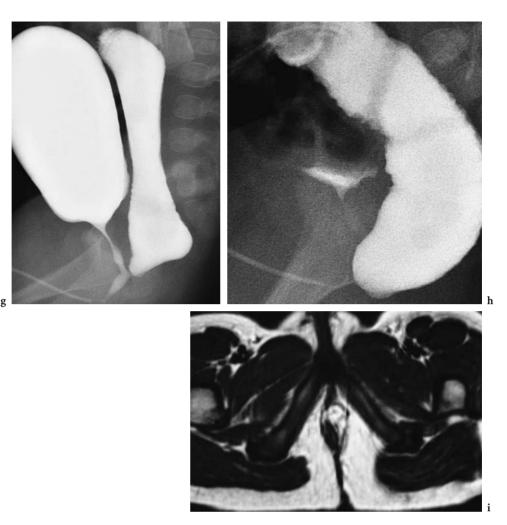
a Abdominal radiograph on day 1 of life. The bowel is distended with air but this comes to an abrupt end low in the pelvis. Note the associated deficient sacrum. b A prone lateral shoot through radiograph showing the lowest gas filled bowel which is near the radio-opaque marker place in the natal cleft. This is a 'low' anomaly. c A prone lateral shoot through radiograph showing the lowest gas filled bowel which is near the radio-opaque marker place in the natal cleft. This is a 'low' anomaly. c A prone lateral shoot through radiograph showing the lowest gas filled bowel which is near the radio-opaque marker place in the natal cleft. This is a higher anomaly. d Renal US showing crossed fused ectopia in an infant with an anorectal malformation. The fused right and left kidneys are shown by the markers. e Spine ultrasound in the patient shown in (a) showing the deficient sacrum, the cord was normal. f T2-weighted sagittal sequence of the spine showing the partly absent sacrum. g A 'fistula' inserting into the posterior urethra of a male infant. h Loopogram study demonstrating distension of the distal colon with retrograde filling of the bladder via the very narrow fistula. i MR of the pelvic floor following surgery showing mesenteric fat that has inadvertently been brought down into the rectal complex
